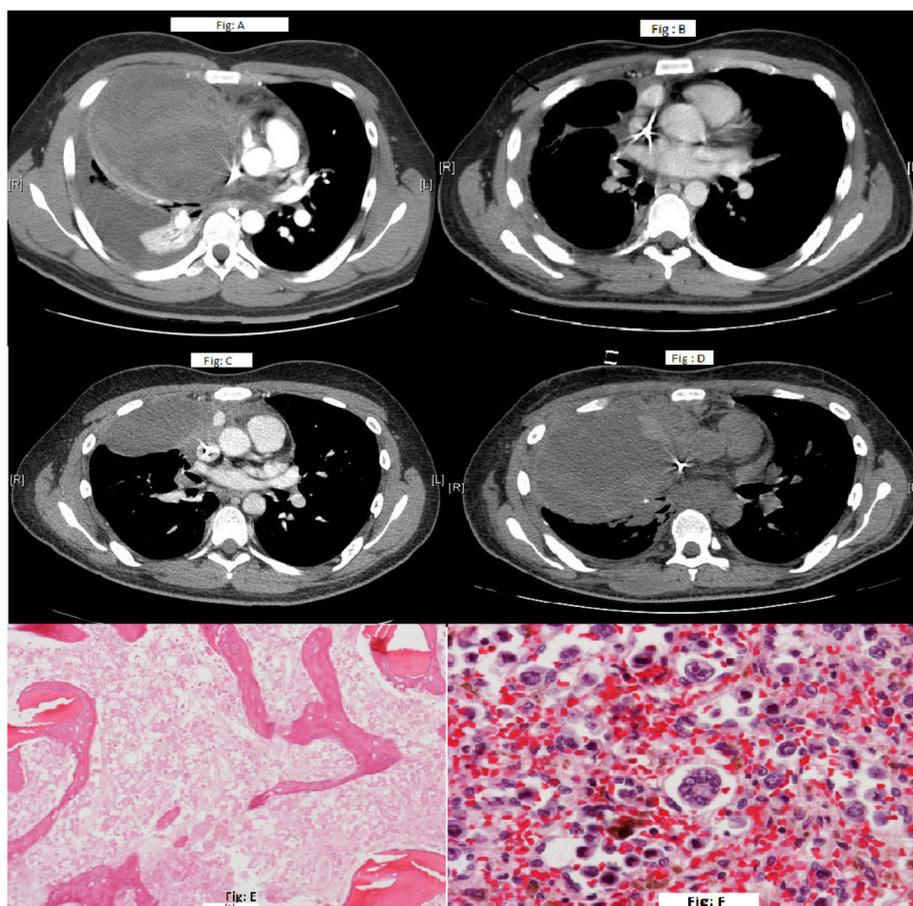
(A) Computed tomography (CT) chest scan showing mediastinal mass at initial presentation. (B) CT chest scan after mediastinal mass resection. (C) CT chest scan 3 months after resection showed tumor recurrence. (D) Repeat CT chest scan within 6 weeks of recurrence showing an enlarging mediastinal mass. (E) Bone marrow biopsy showing extensive necrosis. Atypical mononuclear cells were focally present (not pictured). Flow cytometric immunophenotyping revealed a blast population that coexpressed CD41 and CD61, consistent with the diagnosis of acute megakaryoblastic leukemia. (F) Autopsy section of spleen showing dysplastic megakaryocytes and atypical mononuclear cells. Tumor cells were positive for factor VIII and CD117.
